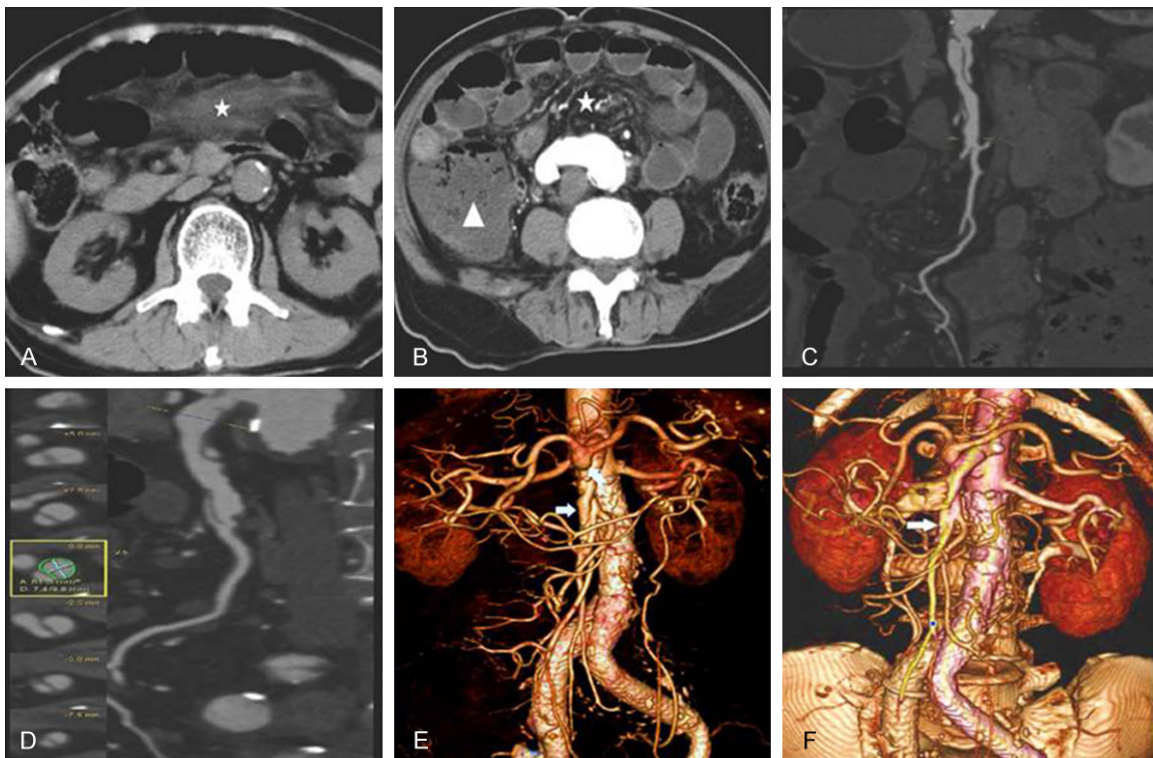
A 59-year-old man with SISMA Type I. Non-contrast axial image shows improvement of edema of mesentery (star) and progression of intestinal obstruction (triangle) from onset (A) to 6th day (B) during conservatively treatment. Curved planar reformations at 1st day (C) and 7th day (D) indicate the dissection with aneurysmal dilatation of false lumen (arrow) under a stable condition. Volume rendering images by initial CTA (E) shows that celiac artery stems from aneurysmal trunk (dovetail arrow) and remains stationary after 3 months conservative management (F).
